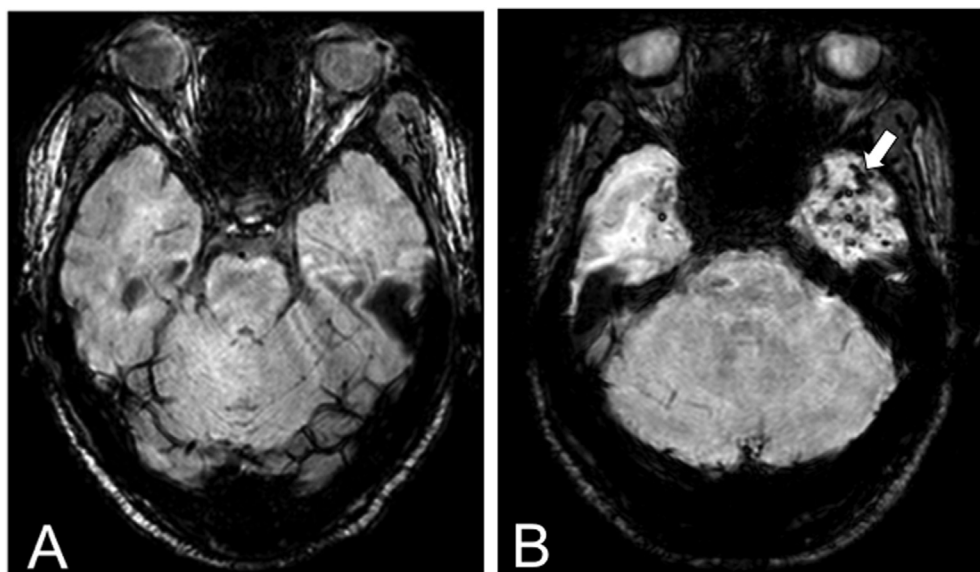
SWI of (A) a 55-year-old male patient without brain necrosis (RN) after radiation therapy. (B) A 50-year-old male patient with brain necrosis. Arrow indicates cerebral microbleeds. *Abbreviations:* RN = radiation-induced brain necrosis; SWI = susceptibility-weighted magnetic resonance imaging.
